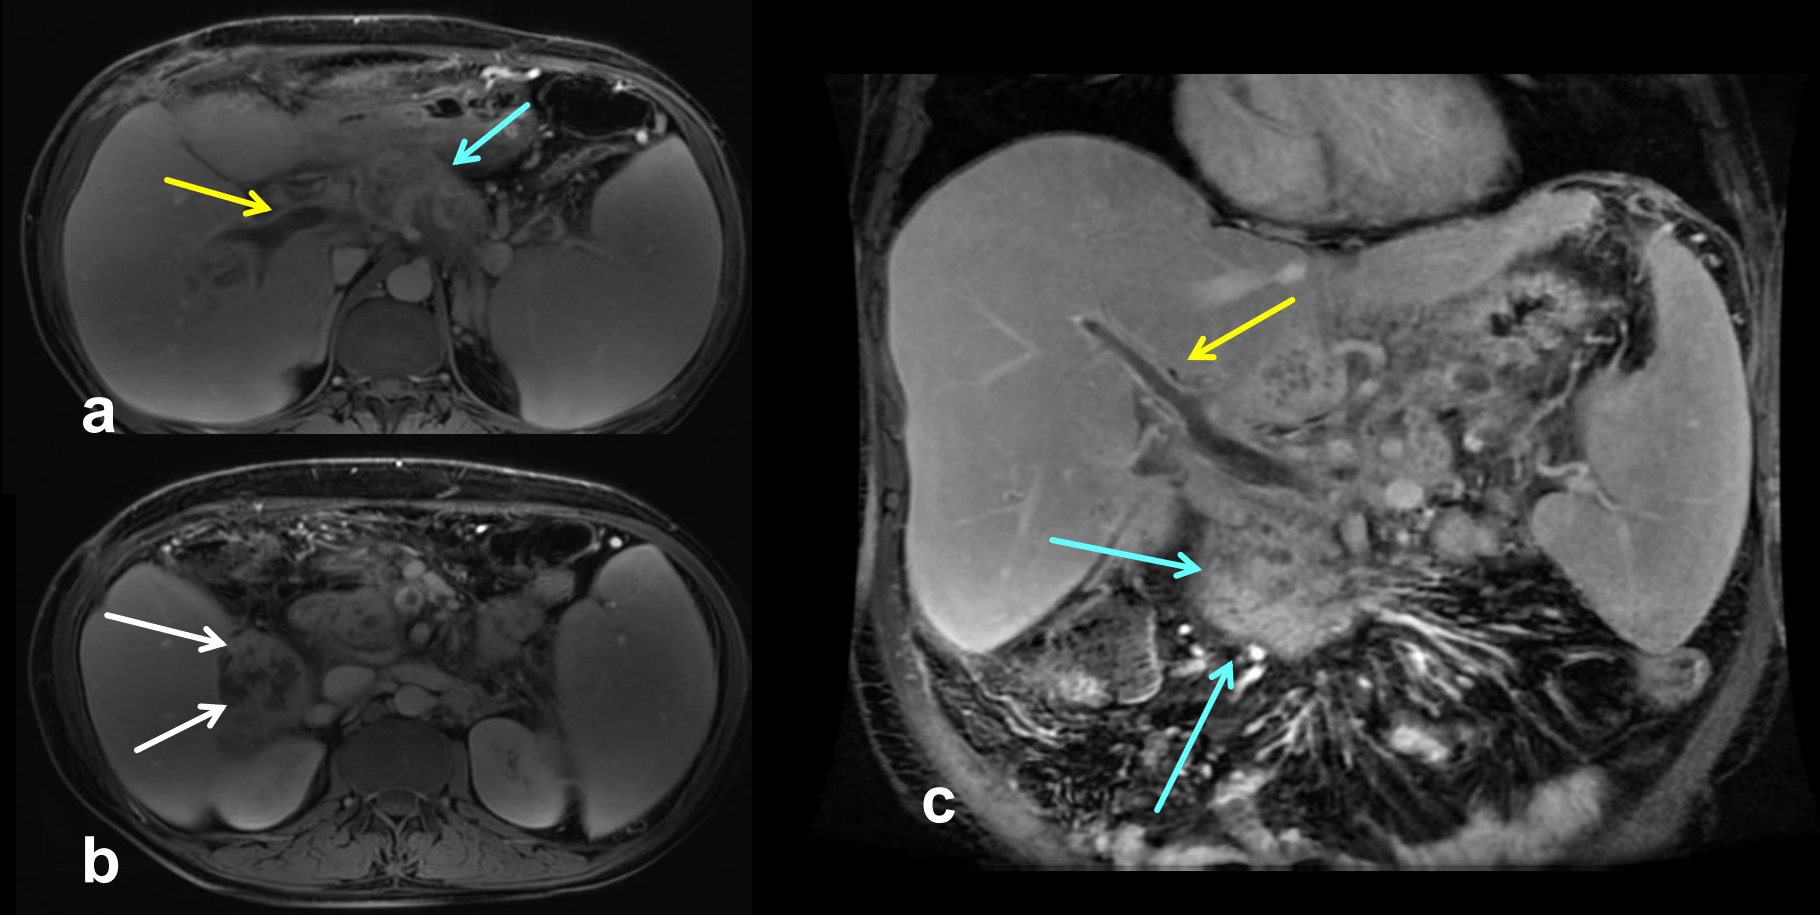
Transverse (a,b) and coronal (c) post contrast MRI - T1WI of a patient with acute pancreatitis complicated by septic portal vein thrombosis (pylephlebitis). Note portal vein and right branch with thickened walls and thrombus (yellow arrows) and enlarged inflamed pancreas (blue arrows). Hepatic abscess is also present (white arrows).
